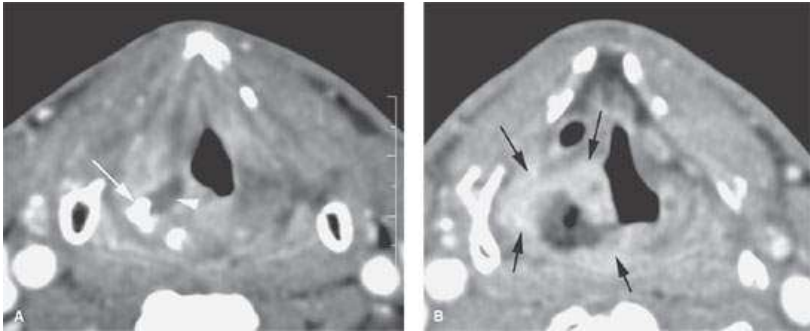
A patient treated with radiotherapy for marginal supraglottic carcinoma. The patient had pain and dysphagia. CECT was done. A: Shows a sclerotic arytenoid (arrow) surrounded by a small fluid filled cavity an appearance consistent with localized arytenoid necrosis. However, more extensive disease was seen superiorly. B: Shows a necrotic appearing mass of the aryepiglottic fold containing fluid and debris and gas. There was surrounding enhancing mass (arrows). At this point one cannot be certain whether this represents an extensive arytenoid necrosis or coexistent necrosis and tumor. A period of conservative management failed to produce any resolution. Biopsy revealed recurrent tumor. (Note: In this case the extent of the soft tissue changes is more than that usually seen in a simple arytenoid necrosis but that was still a distinct possibility and such changes can resolve and the larynx heal. These cases require close surveillance since when a mass is this extensive recurrent tumor becomes much more possible. FDG PET in these situations usually is not helpful since the radiolnuclide study is hypermetabolic in both the reactive usually infected processes as well as in recurrent tumor. A negative FDG PET would support necrosis.)
